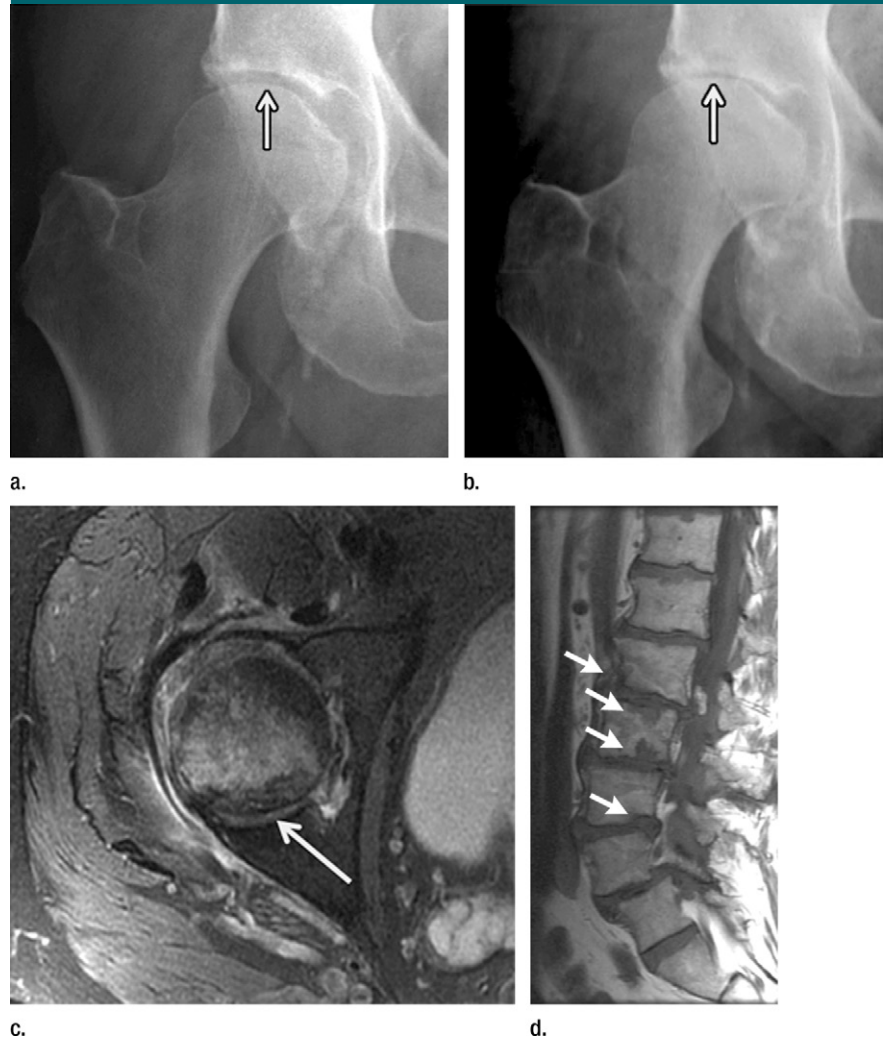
Insufficiency fracture of the femoral head. (a, b) Increasing joint space narrowing (arrow) is demonstrated on right hip radiographs over a period of 12 months in a 78-year-old man with increasing clinical symptoms. (c) Axial fluid-sensitive intermediate-weighted fast spin echo image obtained at 12 months shows fracture lines at the posterior aspect of the femoral head (arrow) and a substantial amount of bone marrow edema pattern. (d) Sagittal T1-weighted fast spin echo image of the lumbar spine depicts multiple endplate fractures (arrows) indicating increased fragility of the spine.
